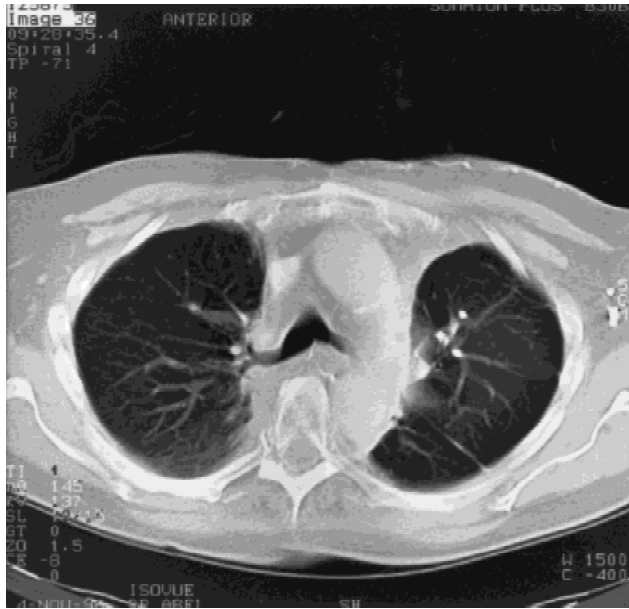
CT scan at 1 year postremoval of Goretex patch demonstrates a normal left mainstem bronchus with no evidence of tumor recurrence.
